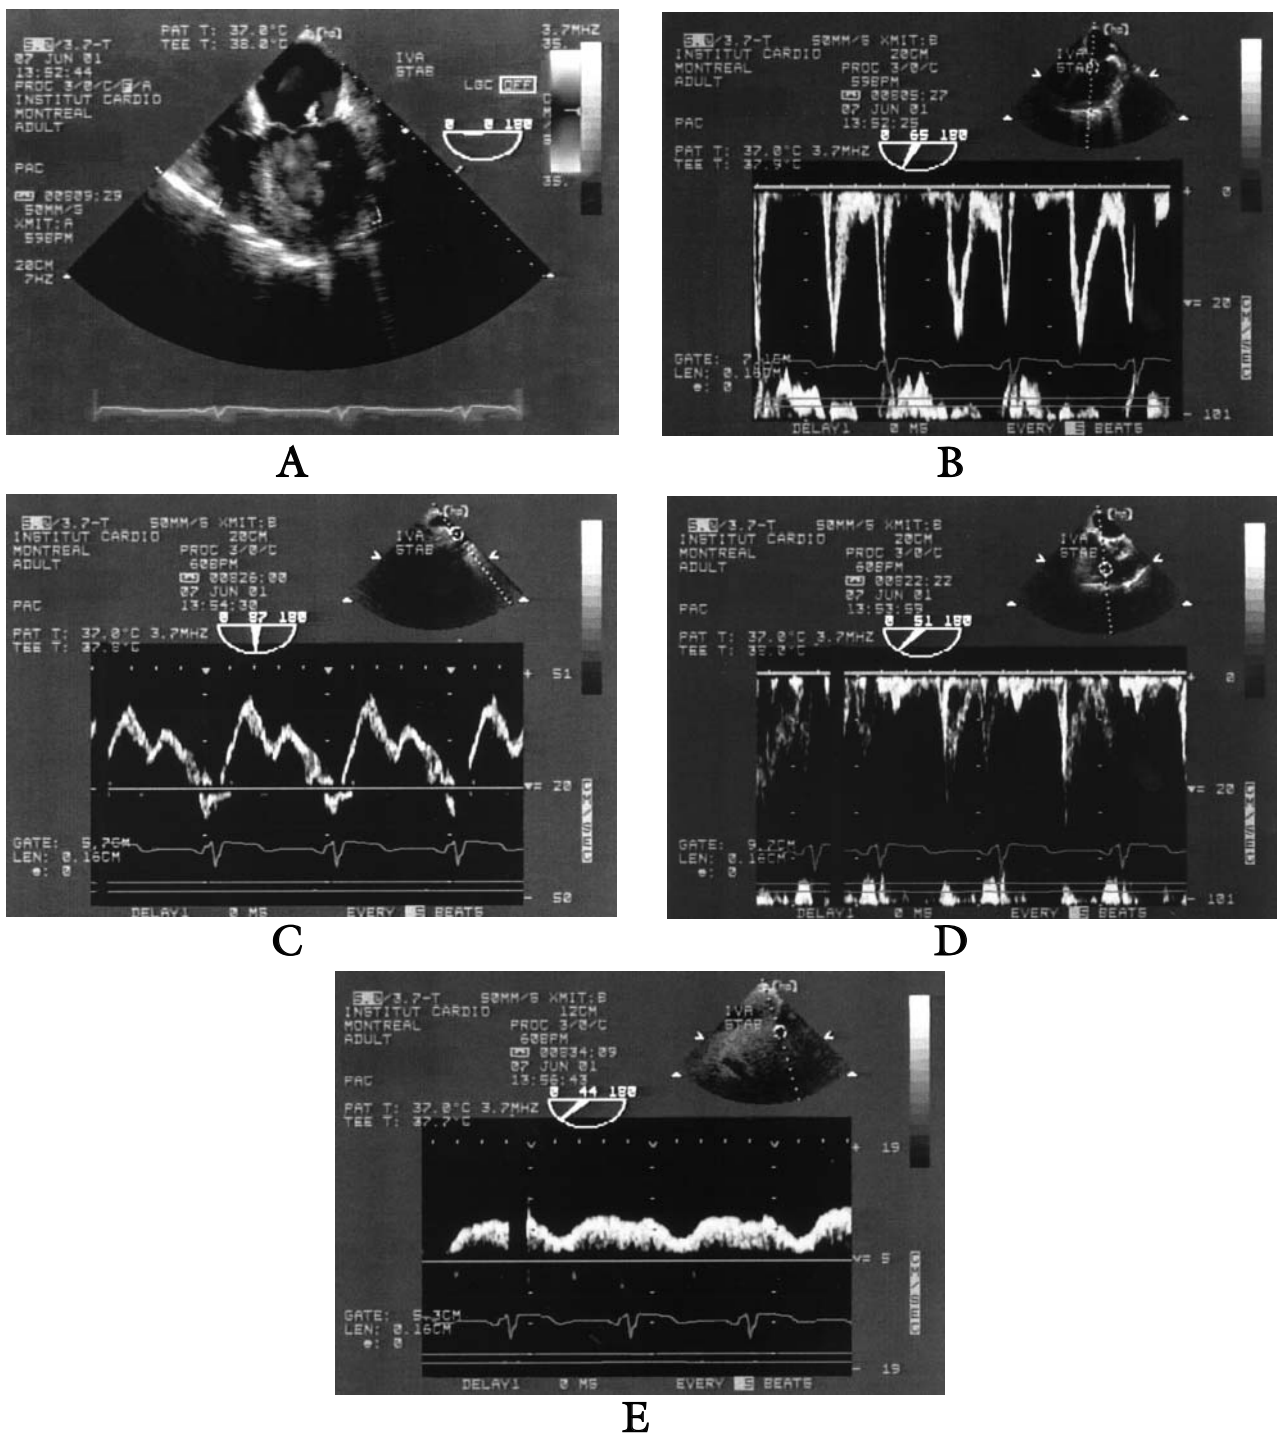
Transesophageal echocardiography findings during inferior vena cava snaring. Findings were compatible with a return to normal right and left diastolic functions. A) mild mitral regurgitation; B) mitral flow E and A wave velocities were 65.8 and 57.3 cm·sec⁻¹ respectively (E/A ratio = 1.19). The E wave deceleration time was 188 msec; C) pulmonary venous flow systolic and diastolic wave velocities were 39.1 and 27.0 cm·sec⁻¹ respectively; D) tricuspid flow E and A wave velocities were 51.5 and 33.6 cm·sec⁻¹ respectively (E/A ratio = 1.53); E) hepatic flow adopted a rather continuous flow, with absence of systolic and diastolic waves.
